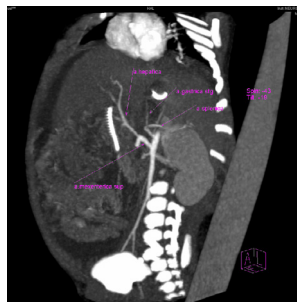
CT angiography, arterial phase: increased diameter of the hepatic artery, micronodular structure of the liver, ascites.
